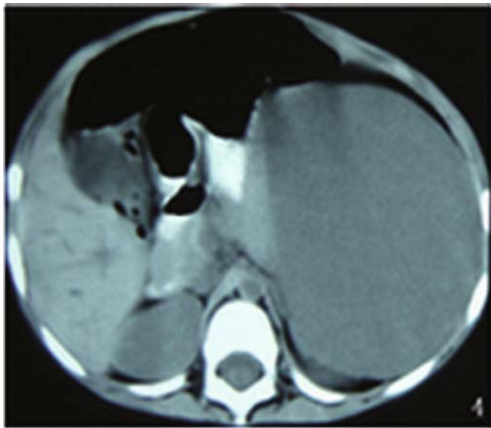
Unenhanced CT showing only homogeneous hypo-attenuation.
